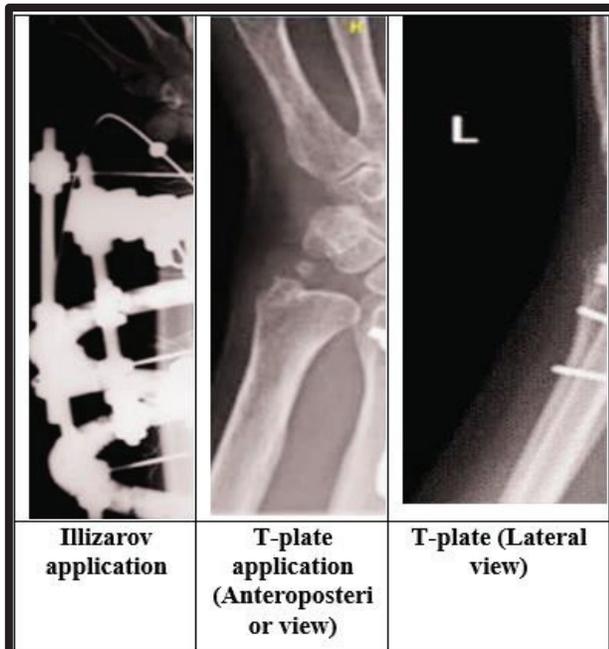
Radiographs of cases for Illizarov and T-plate application.
